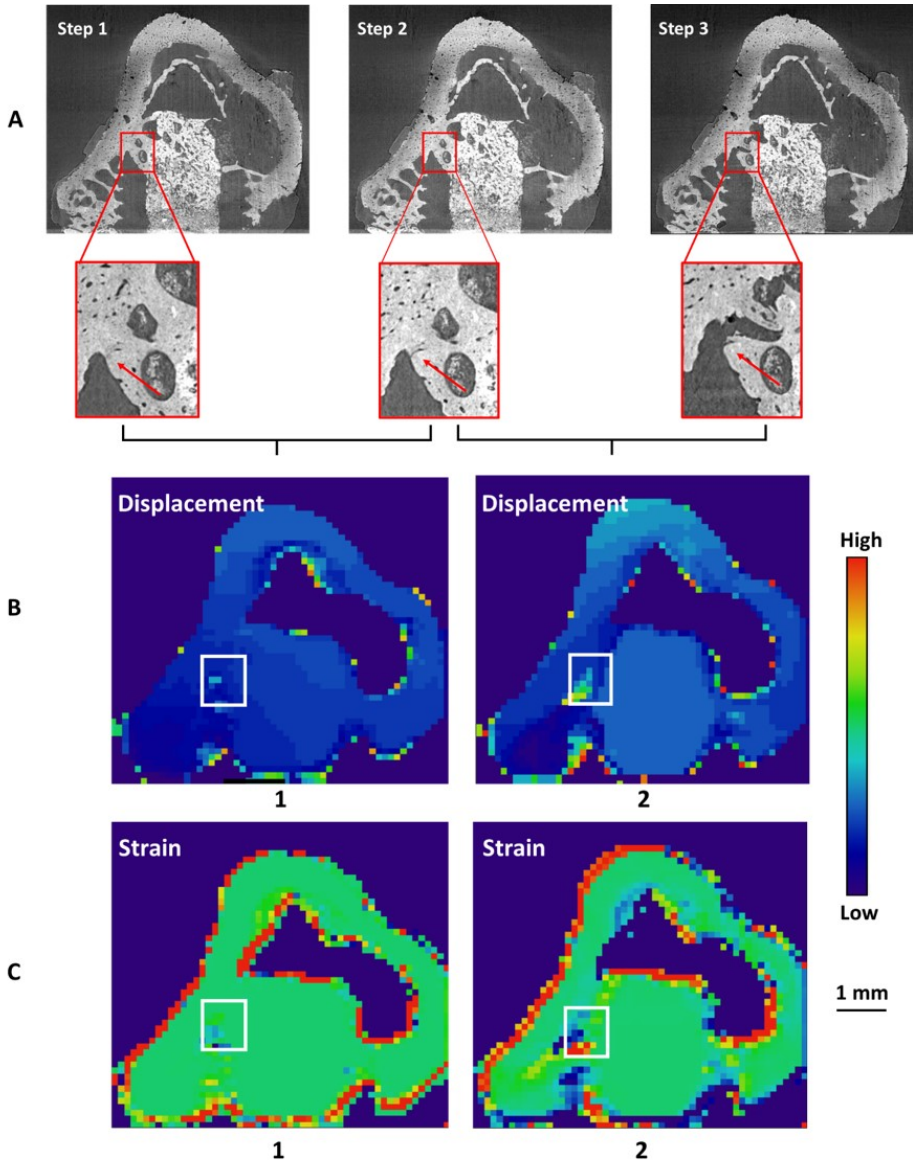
Results of the DVC analyses conducted on bin 4 CT images of the control sample for a crack larger than 10 pixels. For (B-D): the first column shows the resulting fields of the DVC analysis of steps 1-2, and the second column of steps 2-3. (A) CT images with the ROIs containing the large crack for the 3 analyzed loadsteps. (B) Displacement magnitude fields. (C) Strain fields.
